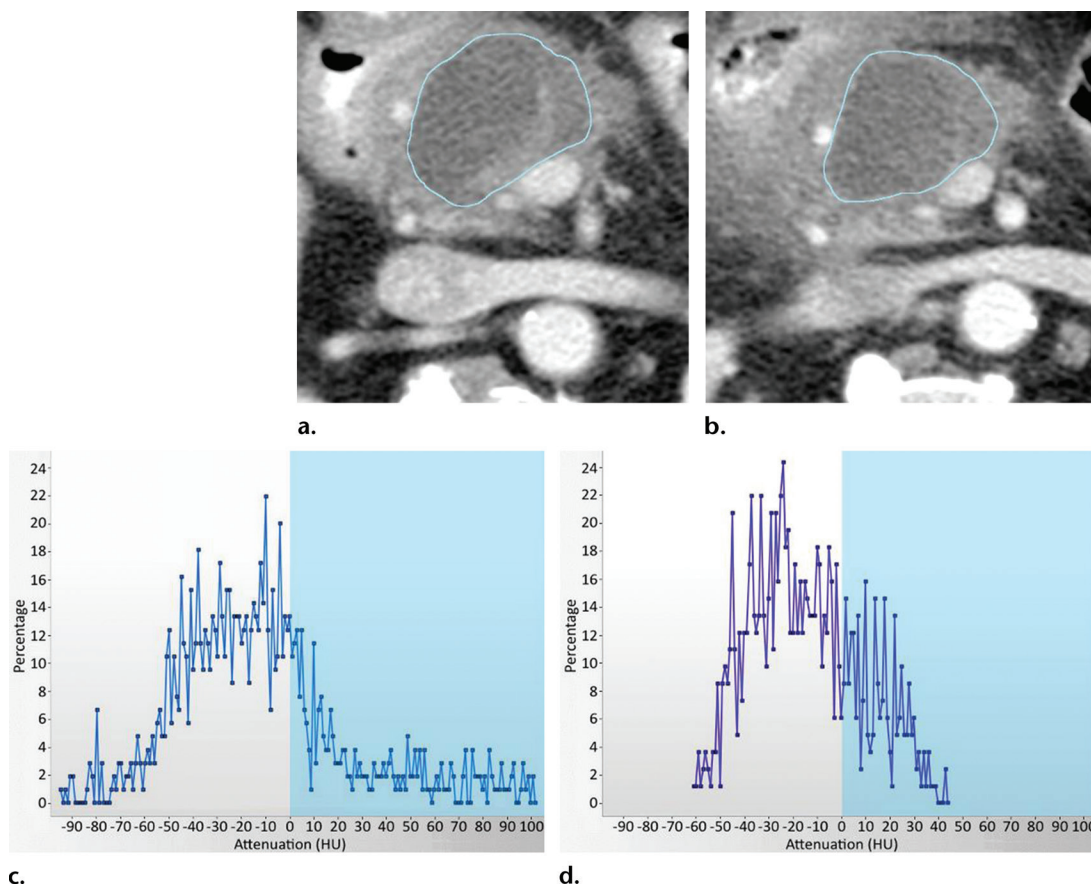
Melanoma. (a, b) Baseline CT image (a) and initial posttherapy CT image after bevacizumab (antiangiogenic) therapy (b) show little change in the lesion. MPP was measured after applying an imaging filter (spatial scaling factor of 4 mm). (c, d) CTTA histograms before (c) and after (d) bevacizumab therapy show a marked reduction in MPP (blue shading), which is associated with increased overall survival.
